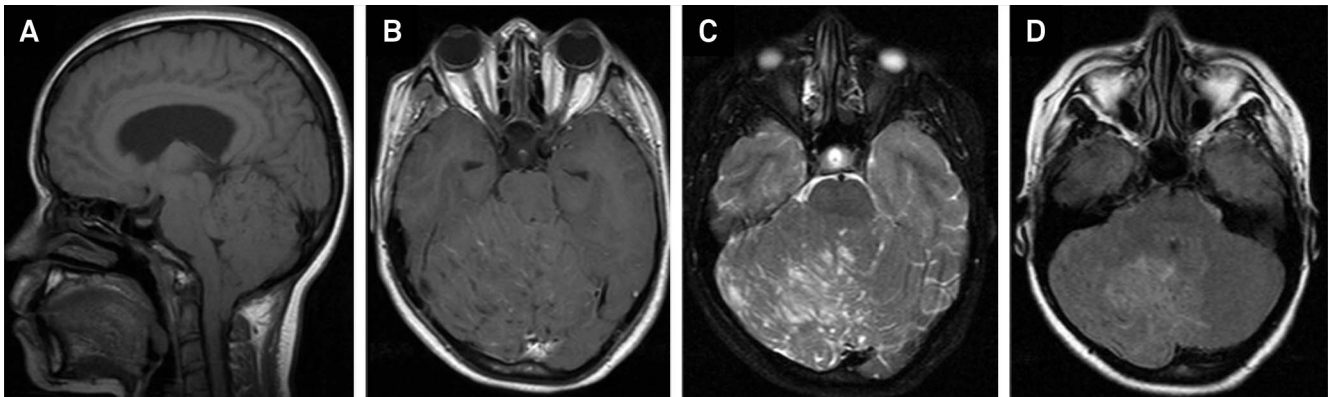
Sagittal T1-weighted MRI showing a superior vermian hypointense mass with brainstem compression and cerebellar tonsil herniation (A). Axial contrast-enhanced T1-weighted MRI unveiling non-enhancing hypointense mass in the right cerebellar hemisphere and vermis with leptomeningeal vessels enhancement in sulci between cerebellar folia (B). Axial T2-weighted (C) and FLAIR MRI sequences (D) disclosing hyperintense gyriiform pattern with enlargement of cerebellar folia and alternate high- and normal-signal bands.
